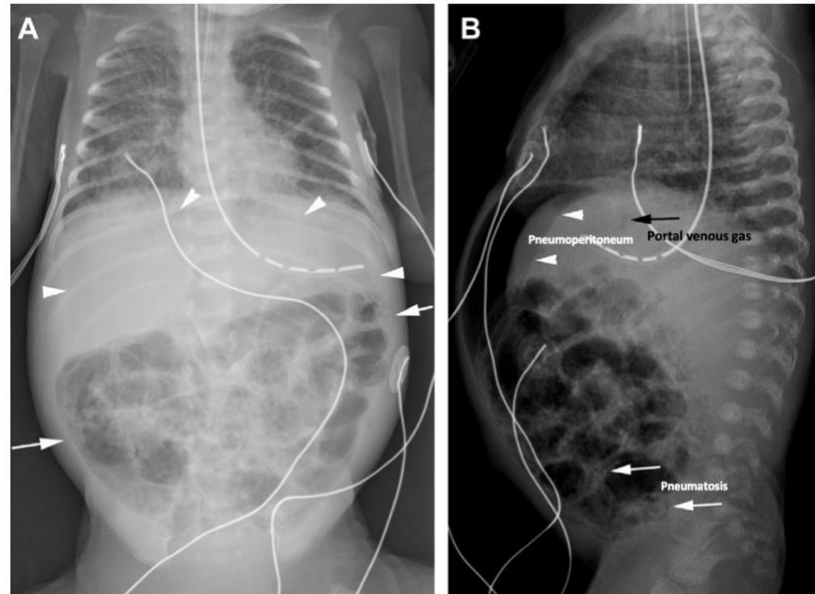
Abdominal radiograph of patient with NEC in (A) supine (B) lateral view showing multiple dilated bowel loops with pneumatosis (white arrow), pneumoperitoneum (white arrowhead) and portal venous gas (black arrow).³
